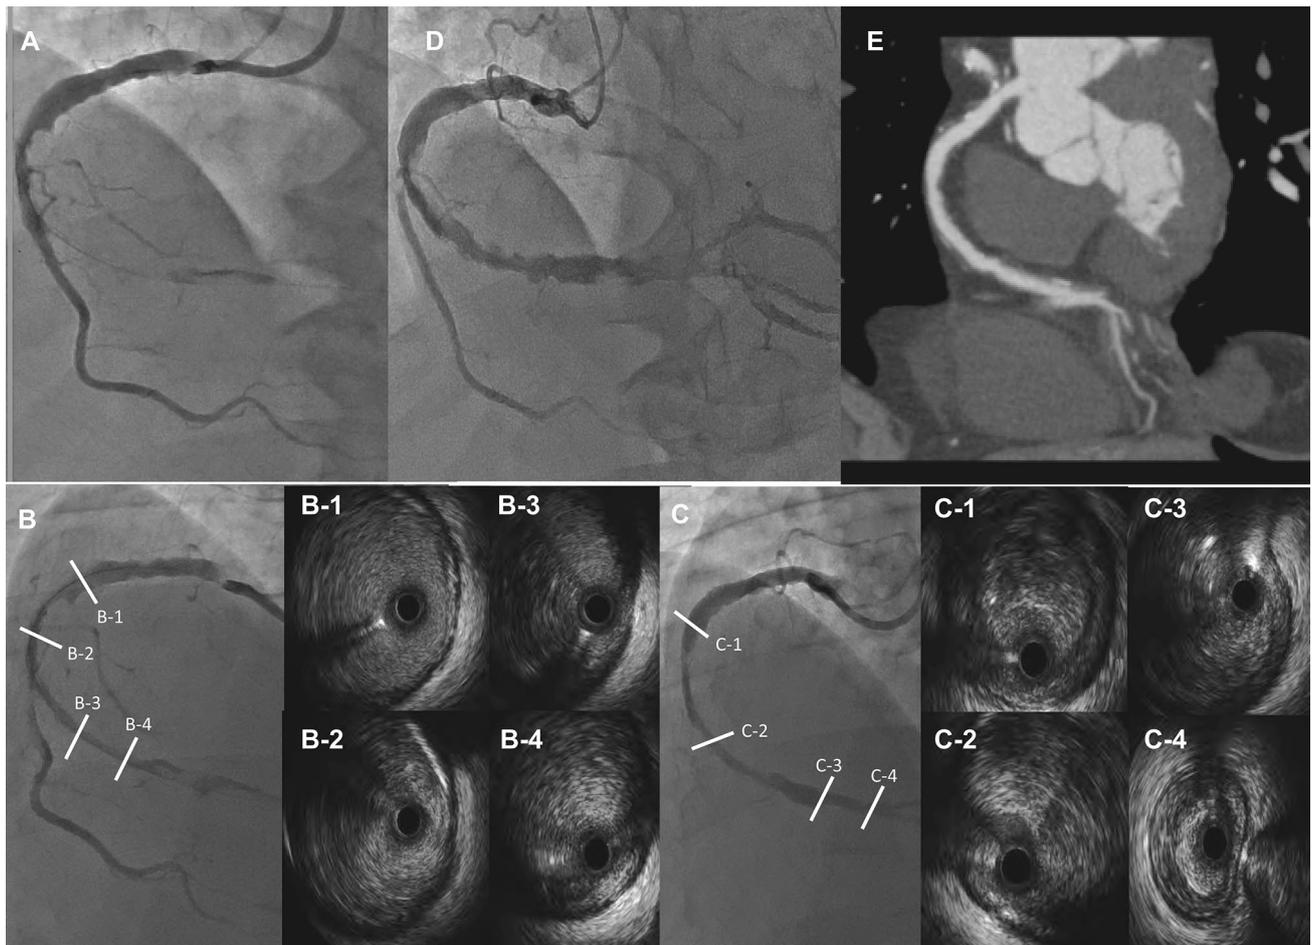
Angiography, IVUS, and coronary computed tomography findings. a Angiography revealed sub-total occlusion of the middle portion of the RCA with ectasia. b Angiography and IVUS findings after ELCA, more than 20 sequences (yellow line), using a 1.7 mm eccentric ELCA catheter and aspiration thrombectomy. c Final angiography and IVUS after ELCA using a 1.4 mm concentric ELCA catheter to
